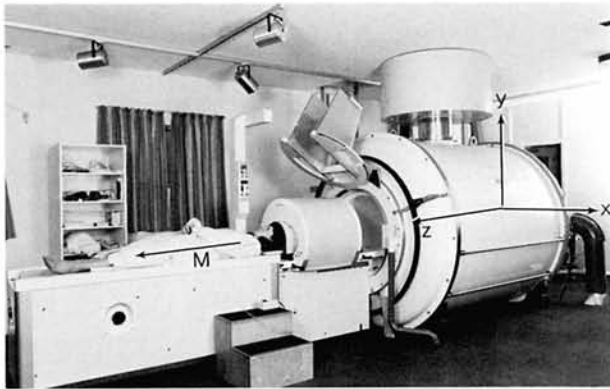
A magnetic resonance imaging machine. The cryomagnet produces a net magnetisation M in the longitudinal axis of the volunteer; 90° pulses are used to rotate this magnetisation into the transverse plane. The x , y , and z axes are shown.
